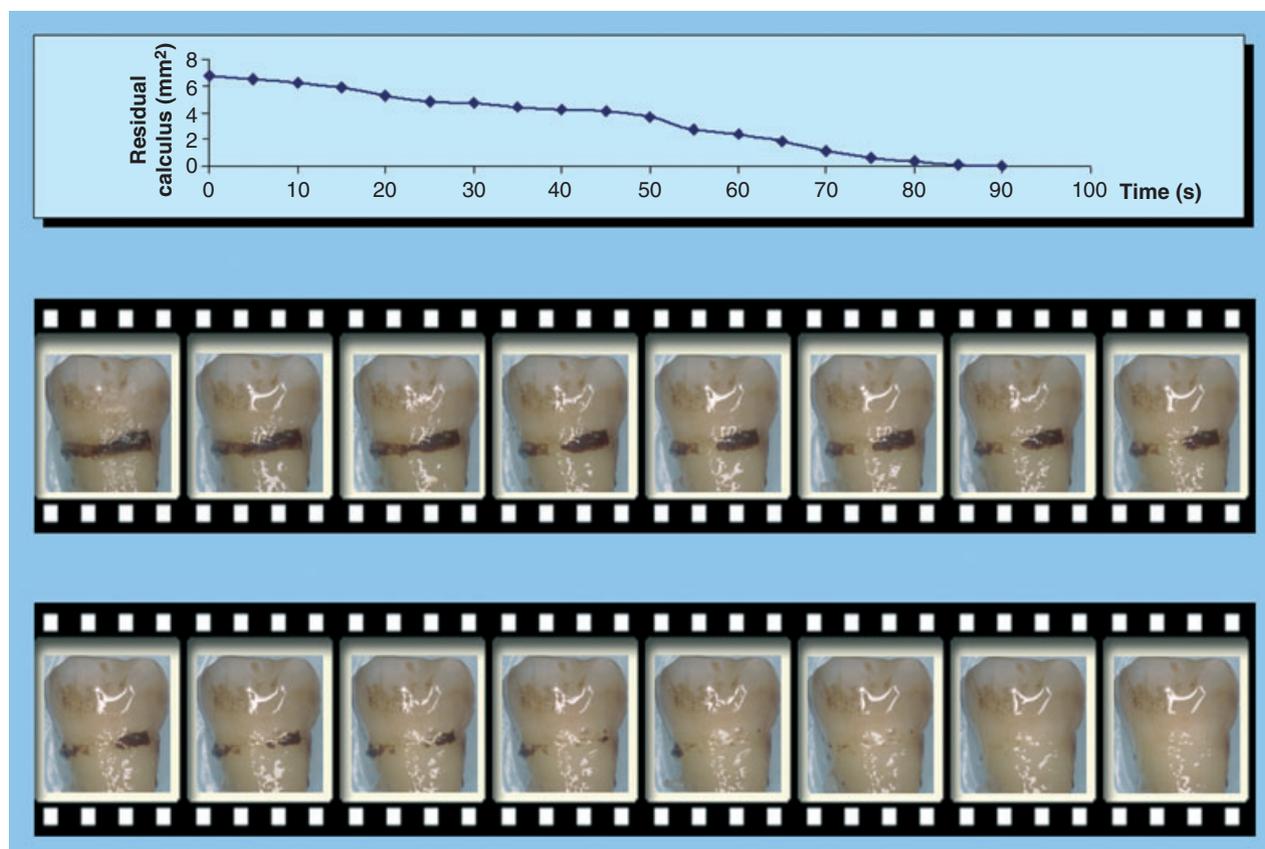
In vitro* effectiveness of calculus removal using an ultrasonic system (EMS ultrasonic system, Nyon, Switzerland). Photographs taken at intervals show the amount of remaining calculus. The chart shows the amount of residual calculus on the tooth at intervals of 10 s.
